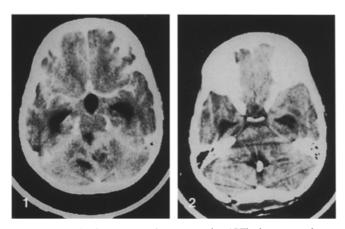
Axial brain computed tomography (CT) demonstrating a large midline vermian tumor filling the IV ventricle and triventricular hydrocephalus (case 1 or case 24 in Table 1)
